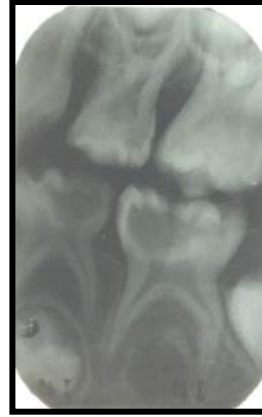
left vertical bitewing
